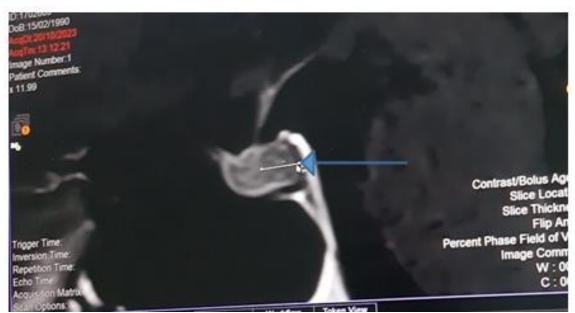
Hypothalamic-pituitary MRI : 3*2 mm picoadenoma of left lobe
